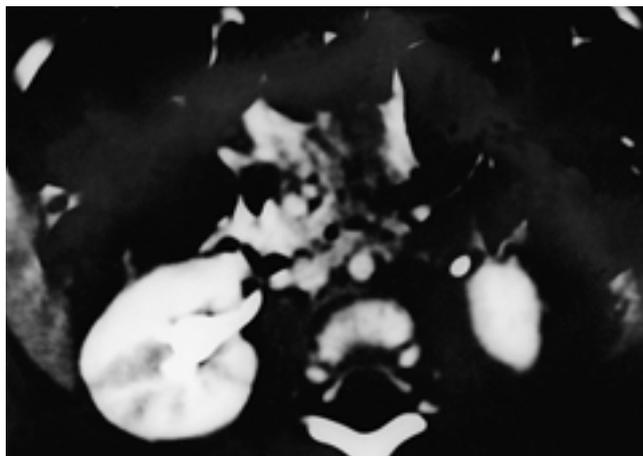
CT pattern IIA in a 3 month-old-boy who had fever for 3 days with 39 , and 9 days of admission periods. Postcontrast CT demonstrates multiple linear and wedge shaped hypo-enhancing lesions in the mid portion of the right kidney.
